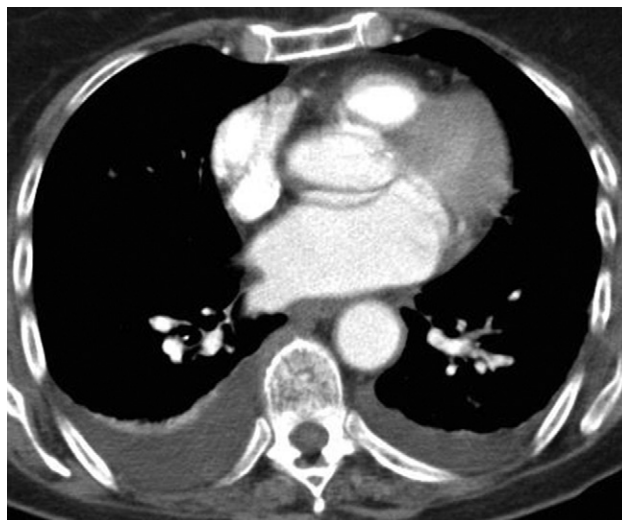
CT of pleural fluid. The bilateral pleural effusions are of homogeneous density, with a CT number between zero and soft tissue. The well-defined meniscus-shaped border with the adjacent lung is typical. The right-sided effusion is causing a little compression collapse of the underlying lung (which shows contrast enhancement).
